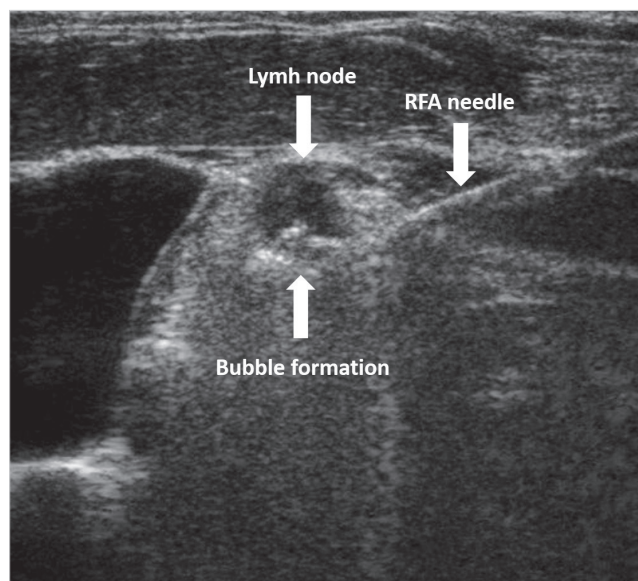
Ultrasonography image showing the bubbling effect due to ablation on the inferior part of the lymph node that was adjacent to the jugular vein.
